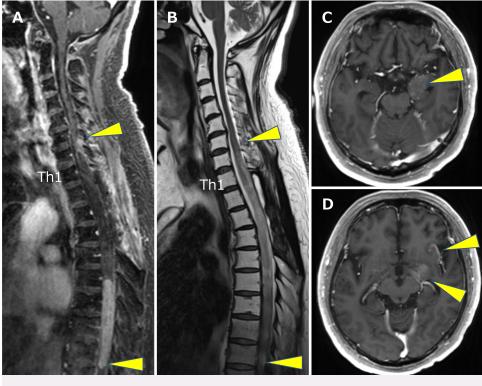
Spinal MRI findings after 13 courses of the BEV plus low-dose ICE regimen. A: Compared with the initial MRI, the mass is markedly increased in size at the C7–T9 levels (outlined by *yellow arrowheads*), especially at the T6–9 levels. B: The degree of peritumoral edema (outlined by *yellow arrowheads*) has also increased. C: Dissemination to the medial temporal lobe is visible (*yellow arrowhead*). D: Dissemination to the insula and the optic tract is also demonstrated (*yellow arrowheads*).
